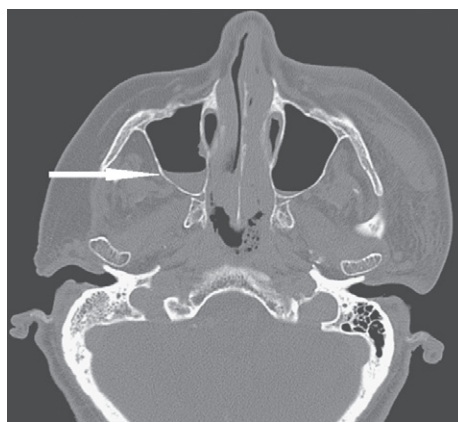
CT of the head through the nasal cavity and maxillary sinuses
